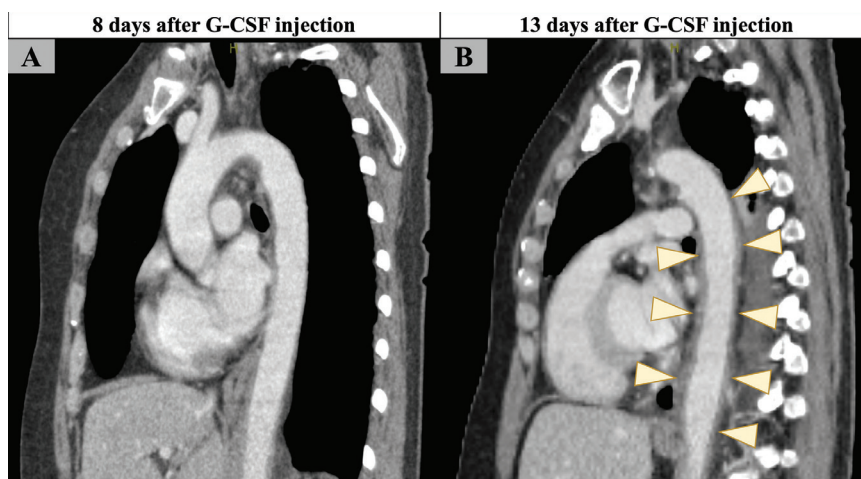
Contrast-enhanced computed tomography scans of the aorta in a febrile 58-year-old woman who had received granulocyte colony-stimulating factor (G-CSF), docetaxel and carboplatin, (A) 8 days after G-CSF administration, showing normal aorta, and (B) 5 days later, showing all-layer circumferential wall thickening of the descending thoracic aorta suggesting aortitis.
